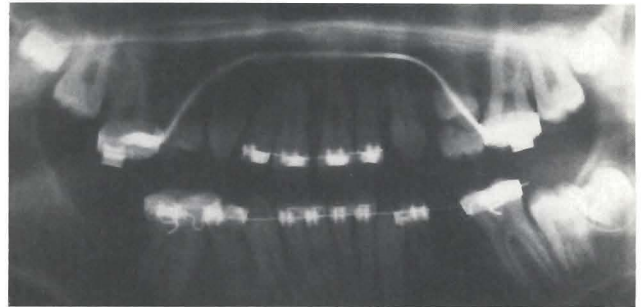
Panoramic radiograph (7/91) showing: (1) excision of inflamed epithelial cyst; (2) teeth numbers 18 and 19 extracted; and (3) patient banded orthodontically.
